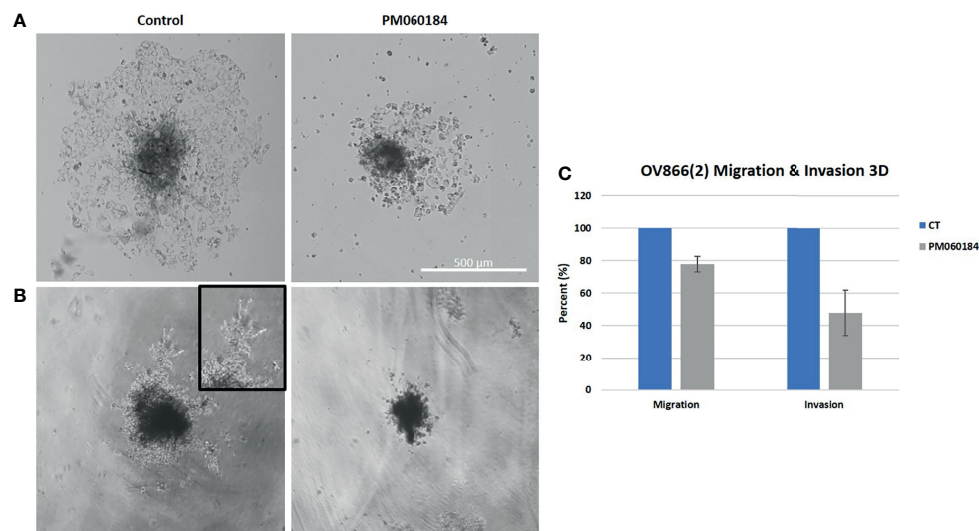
Plocabulin effect on OV866(2) spheroids migration (A) and invasion (B). Pictures are of a representative experiment. (C) Bar plots represent the quantification of the data calculated with the mean values of at least two experiments. CT: untreated control.
